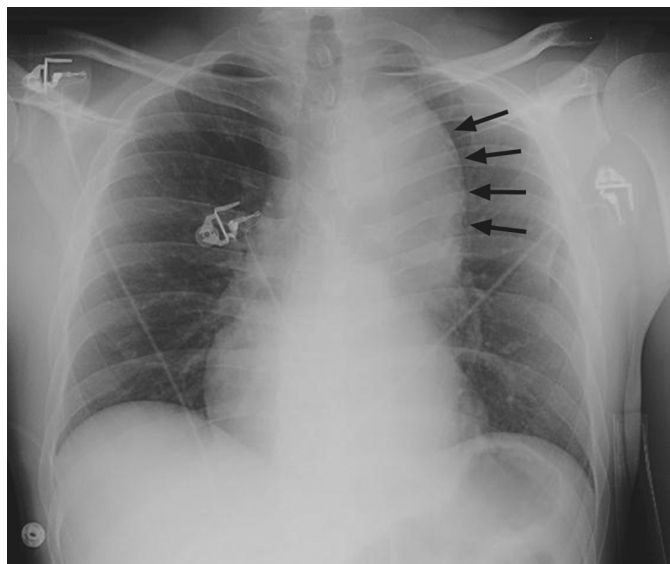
Chest radiograph demonstrating a large descending TAA (arrows).
